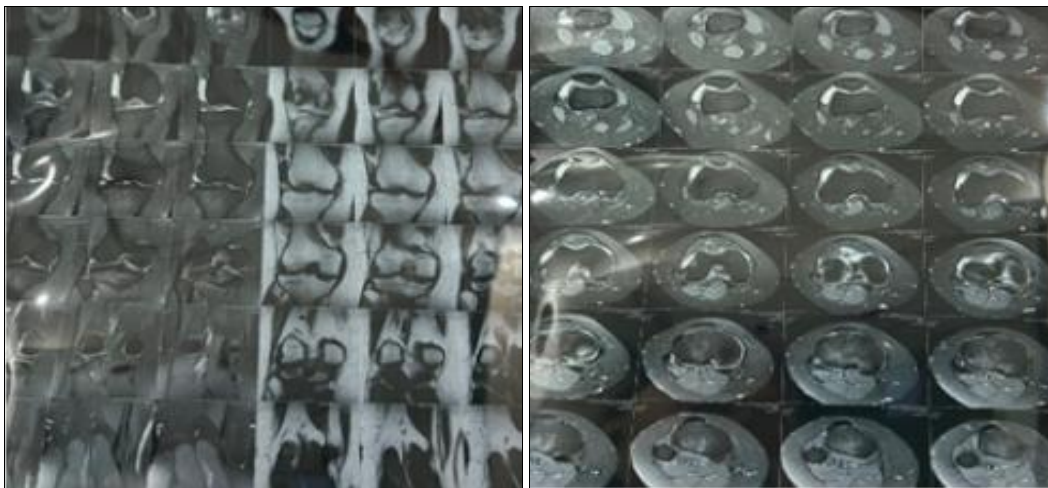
MRI of Right Knee Joint
